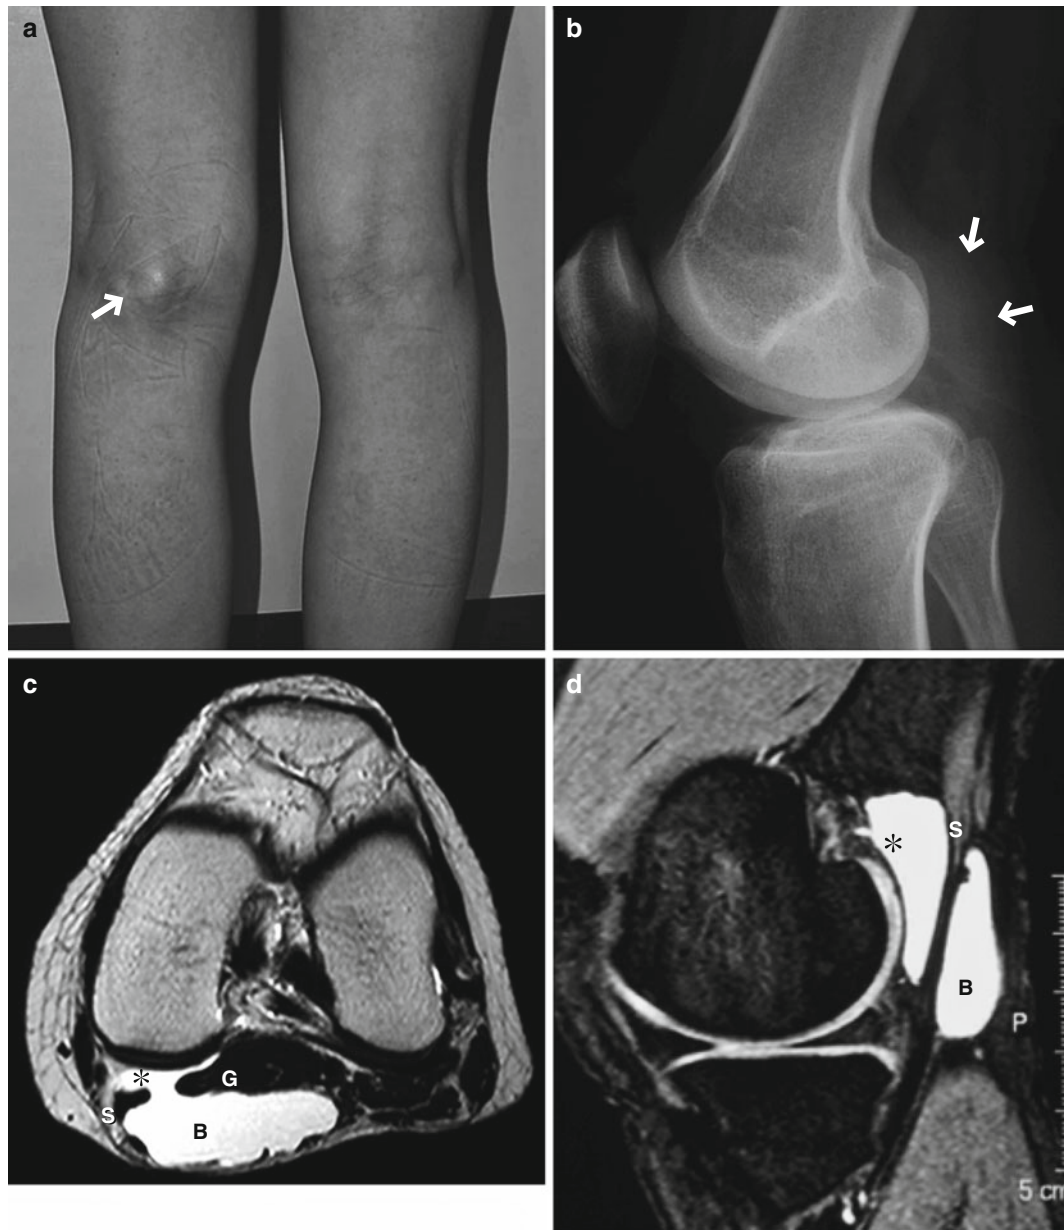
Popliteal cyst. A man in her 20s. (a) Posterior view of the knee, (b) lateral radiograph, (c) axial T2WI, and (d) FS T2*WI. A swelling in the popliteal fossa (*arrow*, a) is noted. On radiograph, there is a soft tissue density in the corresponding location of the posterior knee (*arrows*, b). MRI shows the subgastrocnemius bursa (*)
